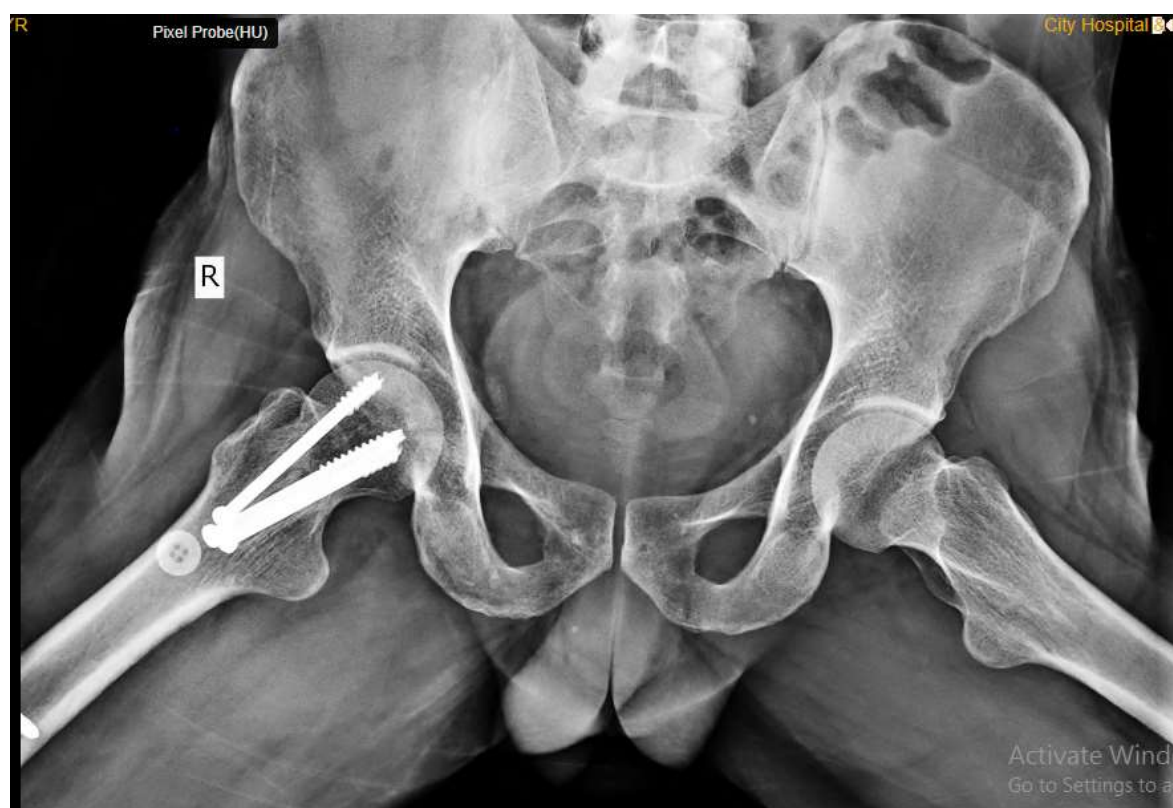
3 months post-operative radiograph of pelvis with both hips frog leg view showing signs of union at neck femur fracture site right side
